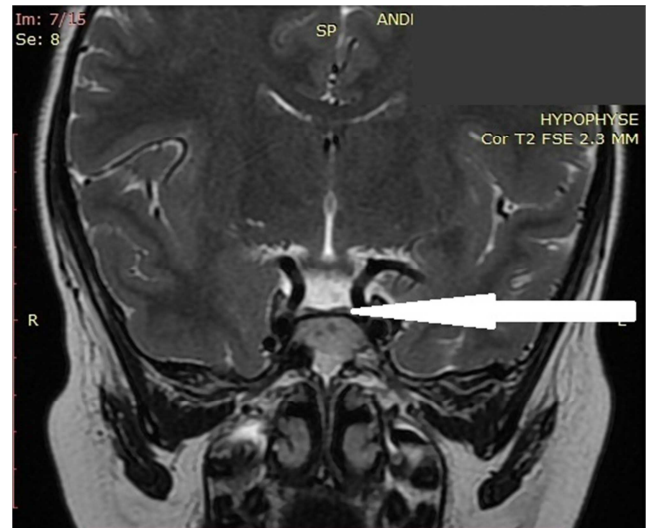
Coronal T2-weighted image showing lack of stalk and small anterior pituitary with homogeneous signal.
